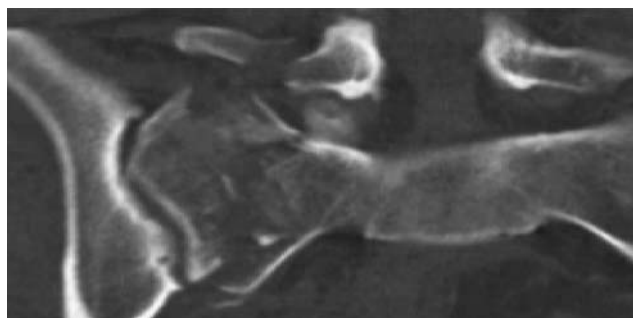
Coronal CT of a patient with concomitant L5 transverse process fracture and ipsilateral pelvic fracture.
